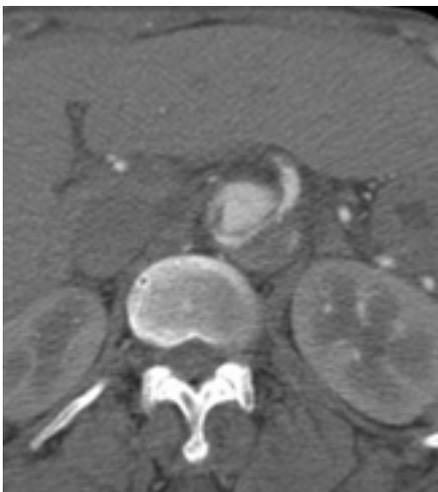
A, B. On CT scan (A) and abdominal aortogram (B), entry tear is noted at the infradiaphragmatic abdominal aorta proximal to the origin of celiac trunk. C. Aortic true lumen and the orifice of celiac trunk are compressed by false lumen and the posterior portion of false lumen is filled with thrombus. D. The diameter of true lumen is slightly restored at the level of SMA origin. However, the orifice of right renal artery is compressed. E. At the left renal artery level, true lumen only is opacified and progression of aortic dissection is terminated with false lumen ending to blind sac.
